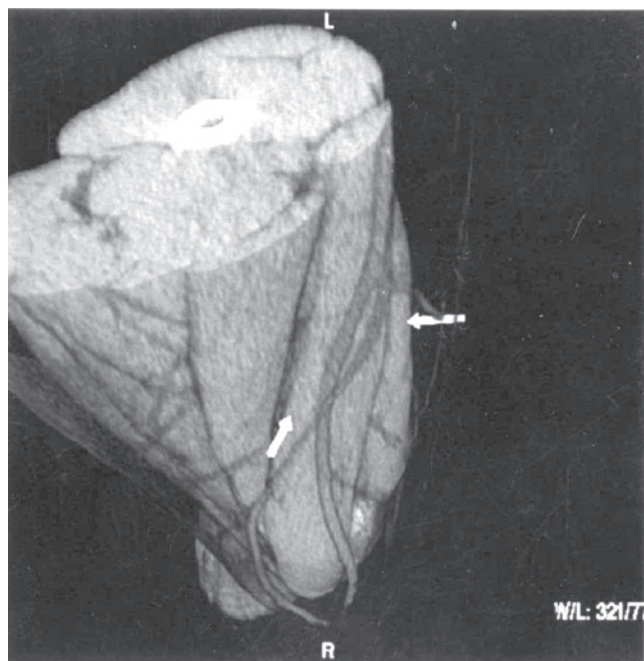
The first contrastless 3D venography by multislice CT (Caggiati, 1999).
